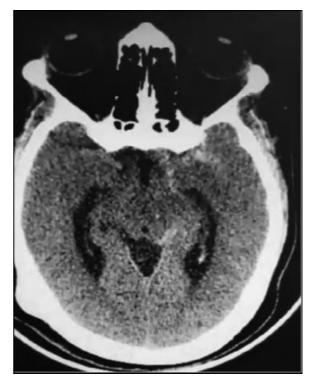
Non-contrast computed tomography with hydrocephaly and subarachnoid hemorrhage (Fisher III).
